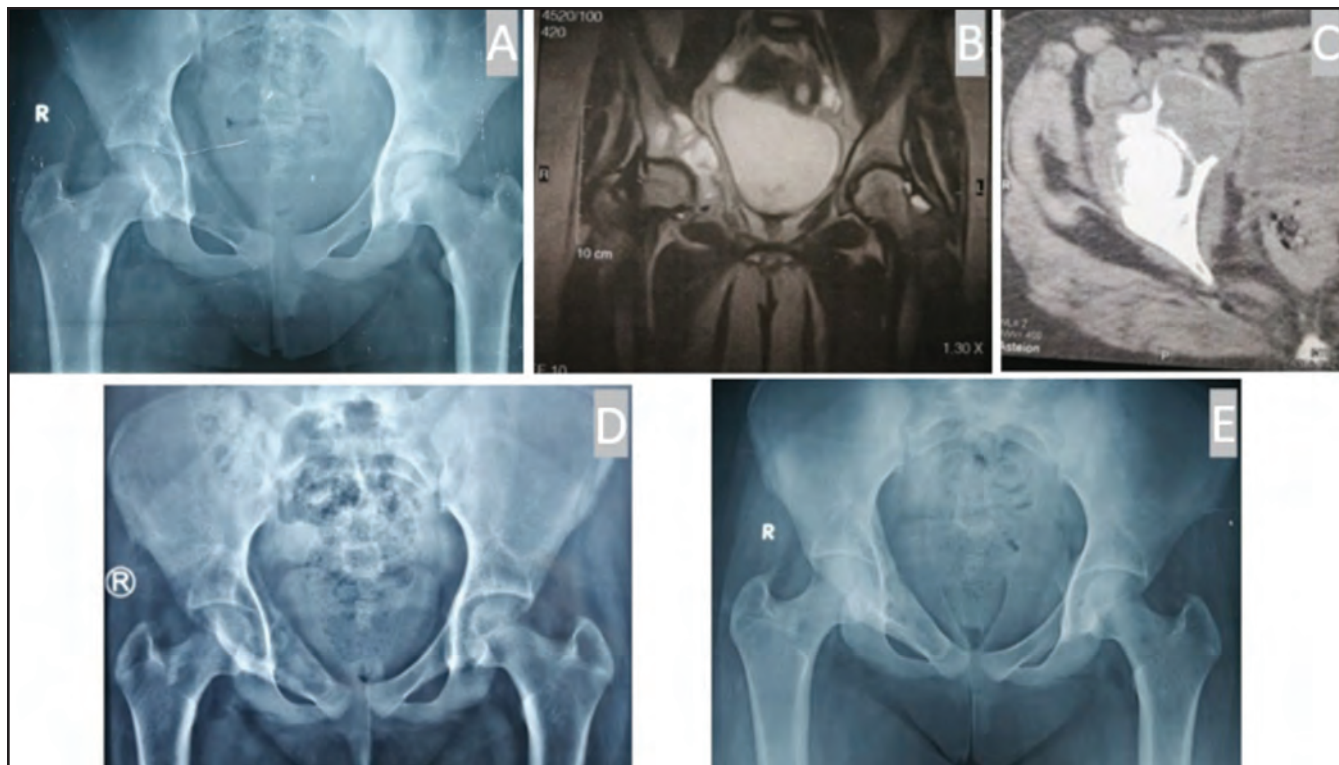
Female patient presented with ABC of the right superior pubic ramus, (A) Plain radiographs with extensive affection of the right pubic ramus. (B, C) MRI images with multiple fluid-fluid levels, (D) Plain radiograph 2months follow-up after extended curettage surgery using high-speed burr, (E) Follow-up radiographs after 12 months with full consolidation of the lesion
